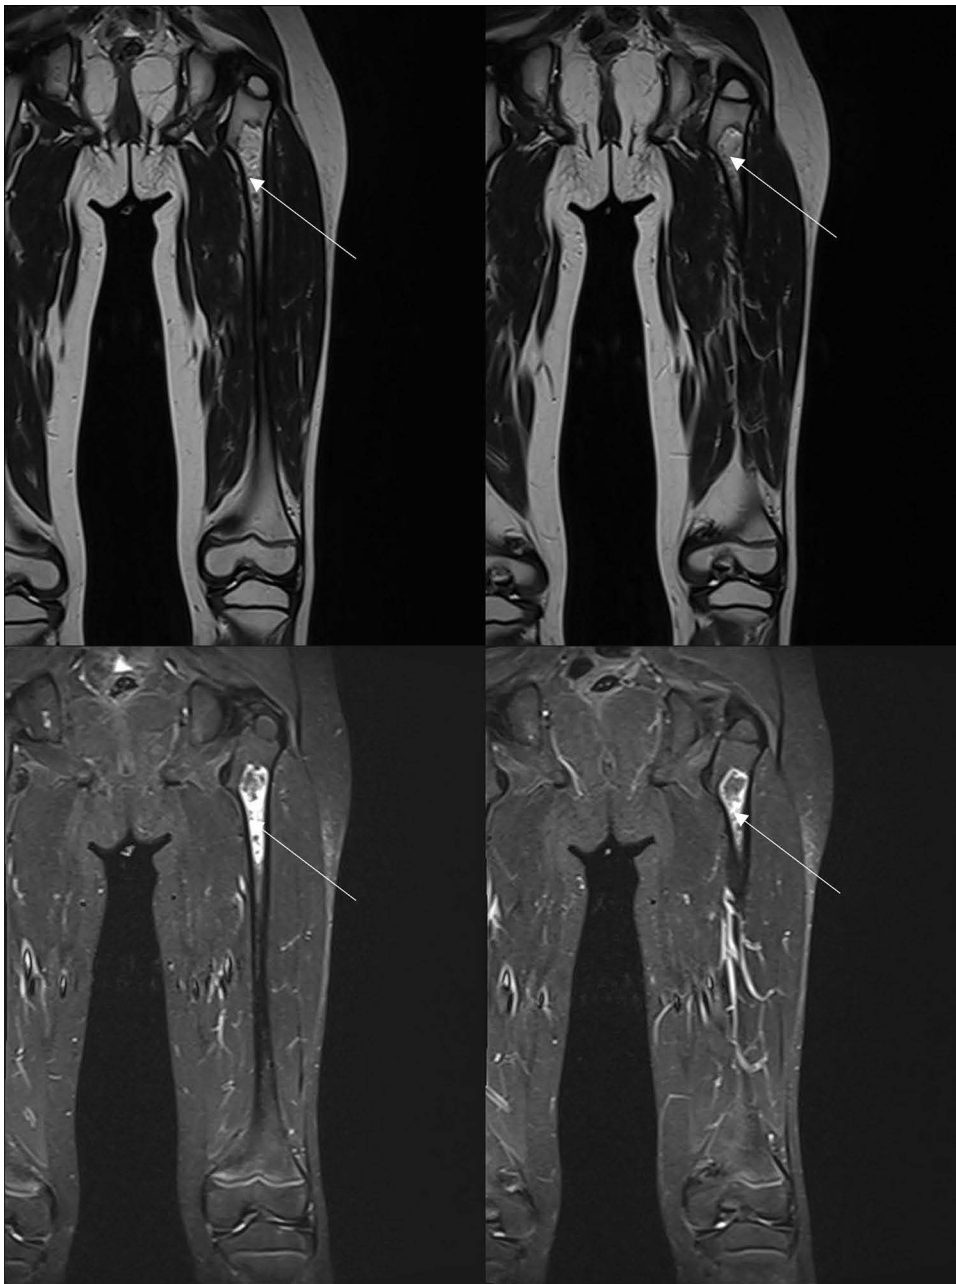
A follow-up MRI in six months after the start of the therapy. In the proximal part of the left femur: oval focal lesion (18 x 17x55 mm), surrounded by a thin sclerotic rim - a picture of bone infarction. The lesion is marked with a white indicator.
